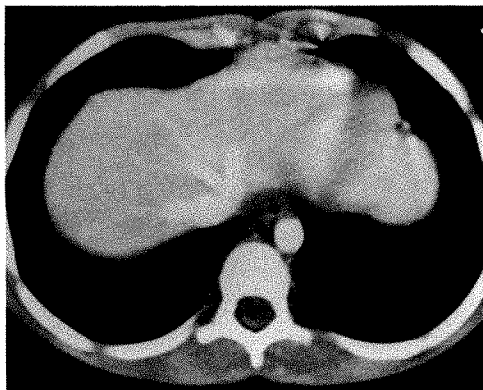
Rapid bolus injection of more than 50% of total IV contrast dose before CT scanning allows excellent vascular enhancement of inferior vena cava and hepatic veins, as well as liver parenchyma in dome of liver.
